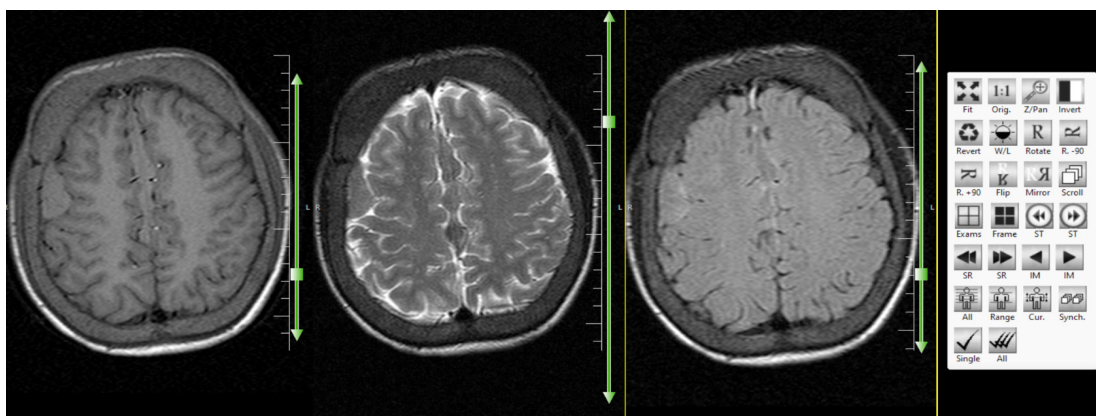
Non-contrast brain Magnetic Resonance Imaging (MRI)
